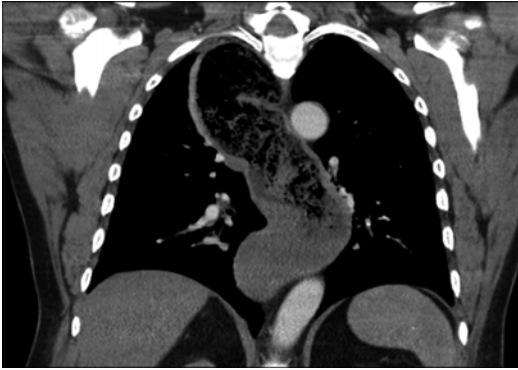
CT scan. Dilated and sigmoid esophagus
